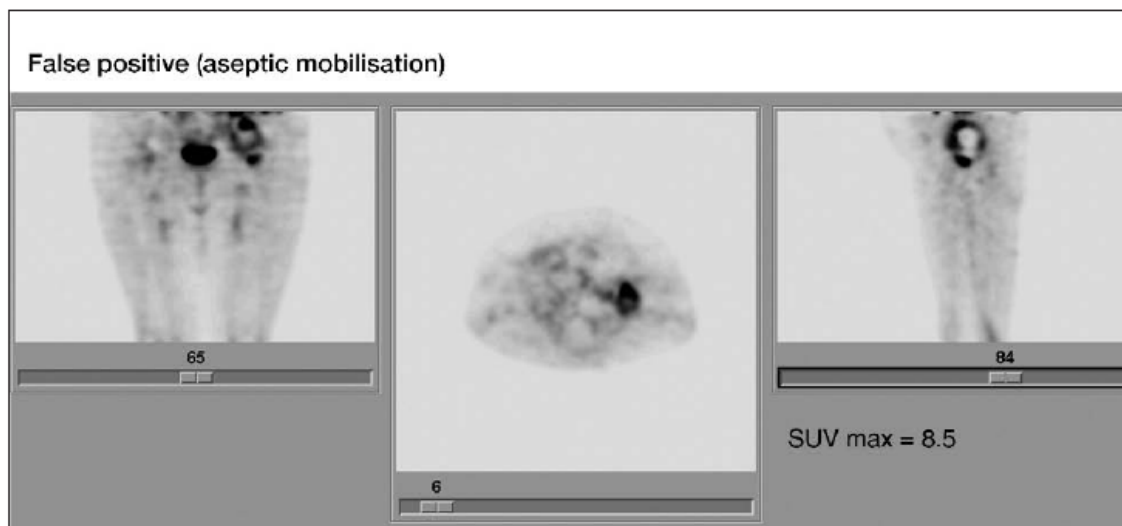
False positive on positron emission tomography (PET); case labelled as infected by PET imaging and which was not. SUVmax: maximum standardised uptake value.
